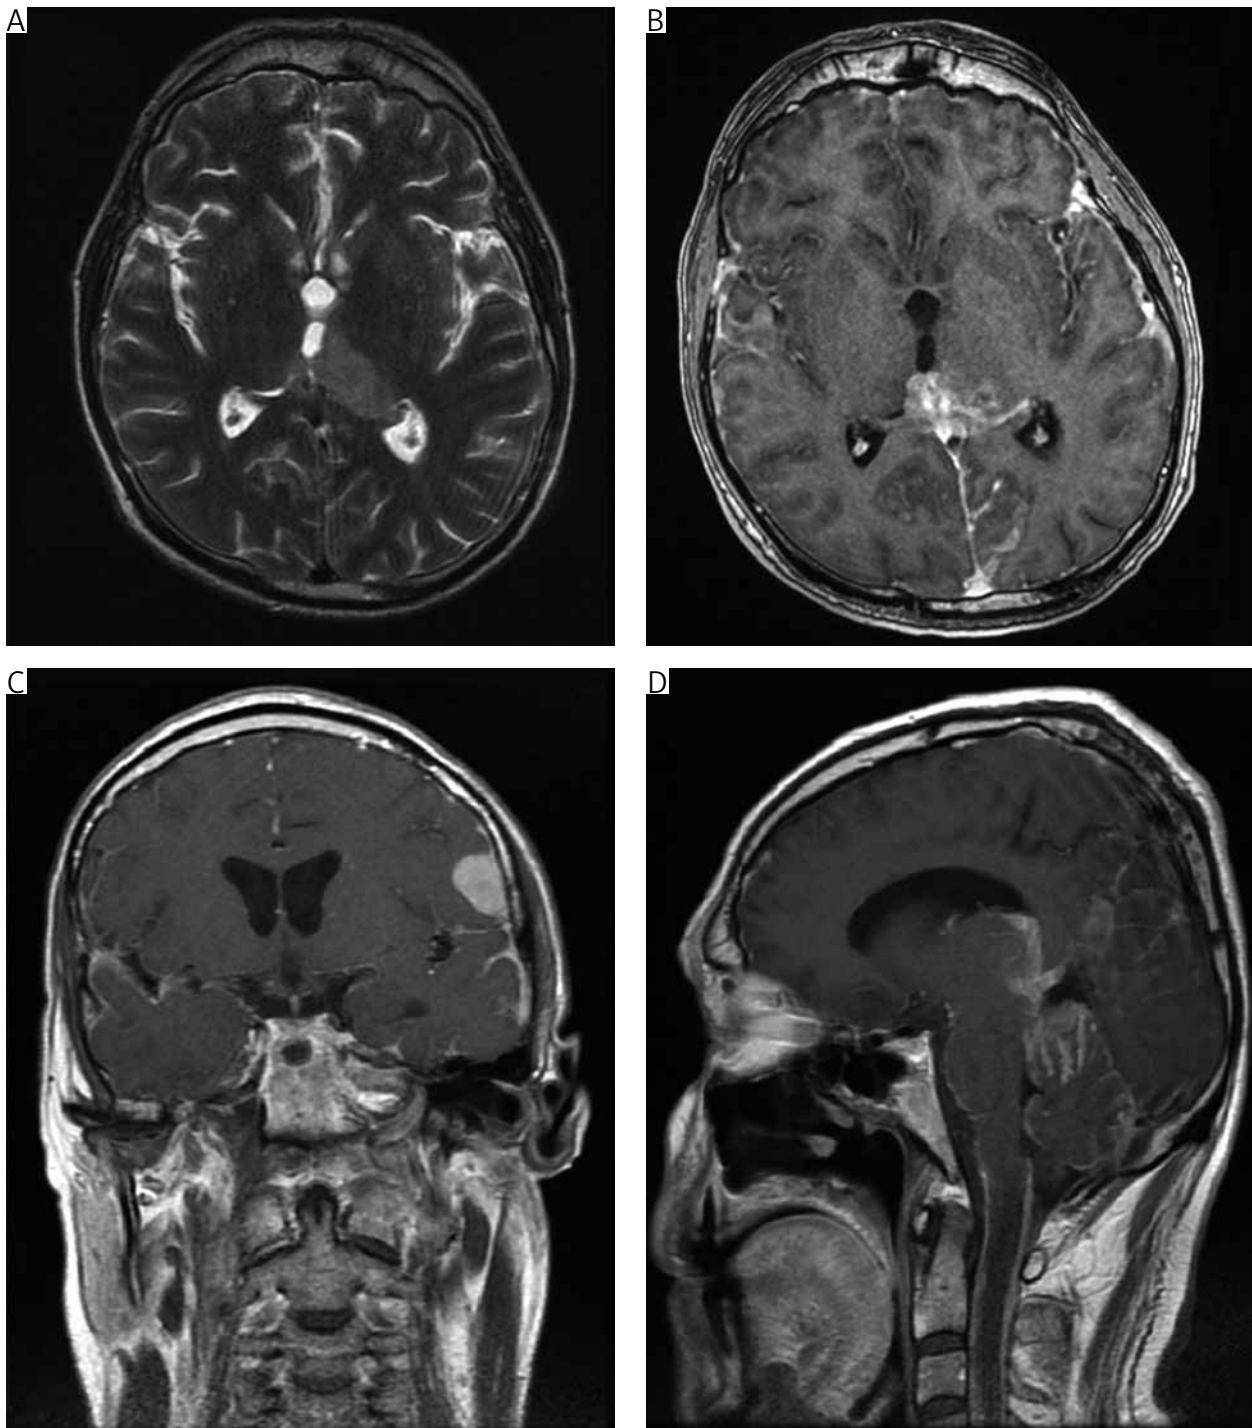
A) T2-weighted axial image showing the pathological mass located in the pulvinar and left thalamus protruding to the third ventricle occupying the pineal region; B) T1-weighted, contrast-enhanced axial image showing the mass in the pineal region and posterior part of the third ventricle; C) T1-weighted contrast-enhanced coronal image showing the mass in the left operculum and widespread subpial dissemination seen in both hemispheres; D) T1-weighted, contrast-enhanced sagittal image showing widespread involvement by the tumour of the cerebral aqueduct, and the subpial space of the cerebellum and the subpial space of the cervical spine
